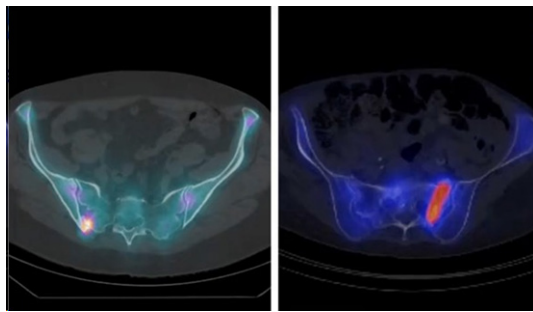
^{99m}Tc-MDP SPECT/CT bone scan of a 57-year-old female with a history of breast cancer who suffers from degenerative hip joints.
